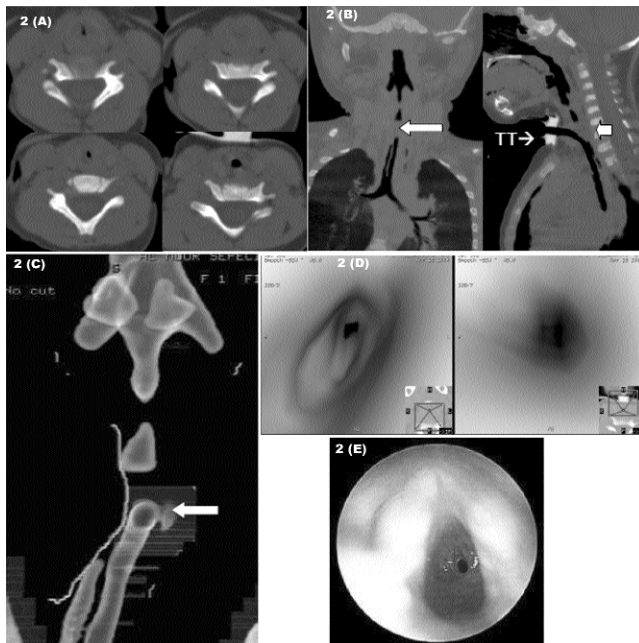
Four-month-old infant with acquired subglottic stenosis from intubation. (a): Axial CT sections show site of stenosis (curved arrow). (b): Coronal and sagittal and reconstruction images show two stenotic segments (the distal stenosis is marked by straight arrow). Tracheostomy tube (TT) is also shown. (c): 3D external reconstruction shows two stenotic segments, cranial one is in subglottic region and caudal one is in trachea; tracheostomy tube is marked by TT. (d) Virtual endoscopic view of stenosis, assessing the stenotic segment from above and below. (e) A close-up view of the stenosis as viewed in conventional endoscopy.
